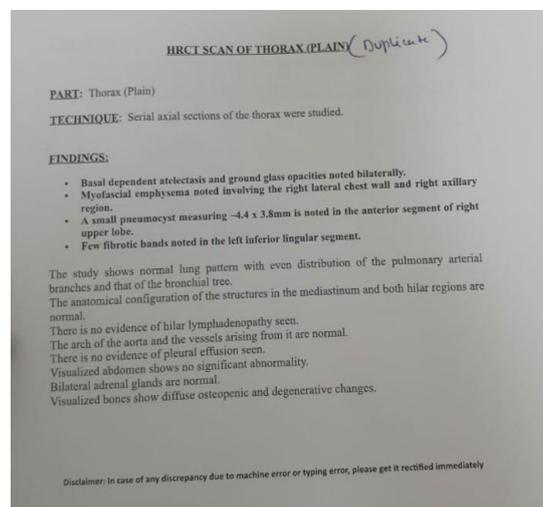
HRCT thorax report after 1 week
